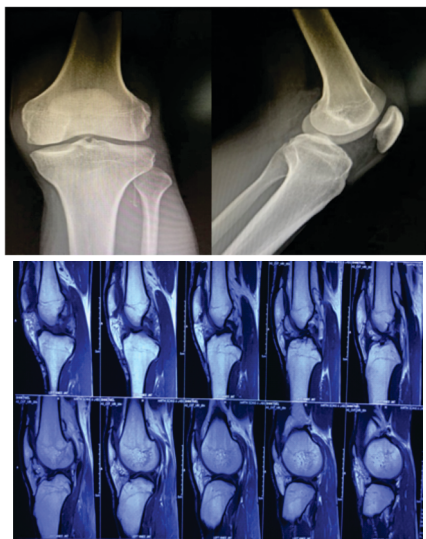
Pre op X-ray of knee AP and lateral shows no bony abnormality and MRI shows Complete ACL tear
